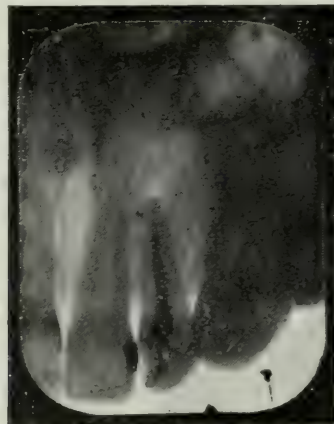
A radiograph of a patient of a fellow-practitioner sent to me for X-Ray diagnosis after several failures of treatments. It shows how carefully the operation had been done and how successful the root filling was, yet still an abscessed area is shown. Advice was amputation, which was done successfully, and to-day the root is carrying a porcelain crown comfortably—crowned, on account of extreme discoloration.
